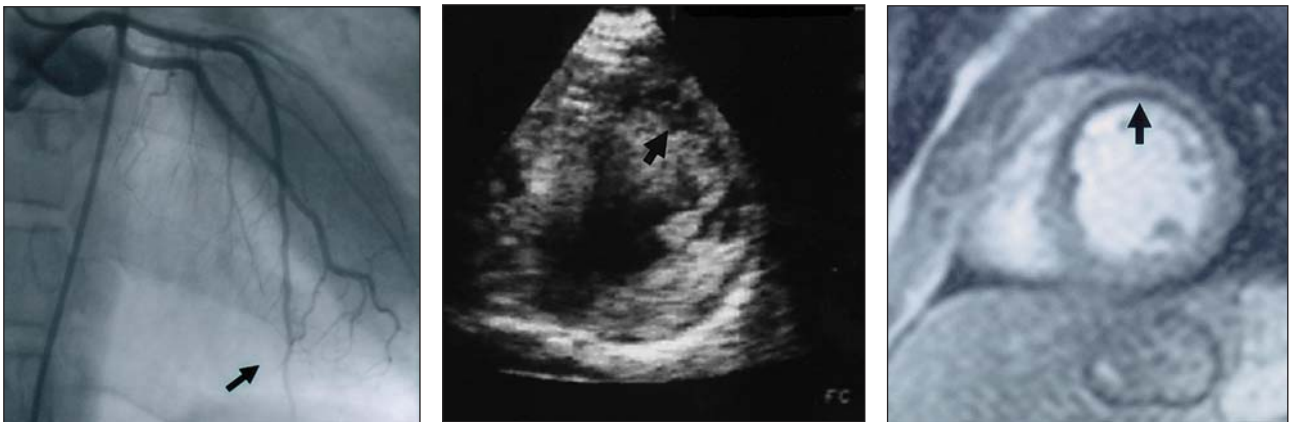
Left: patent descending anterior coronary artery but with blush grade 0 (arrow). Centre: myocardial echocardiographic study with left coronary contrast injection in patient with anterior infarction and no reflow (arrow). Right: magnetic resonance imaging in same patient with no reflow (arrow).
